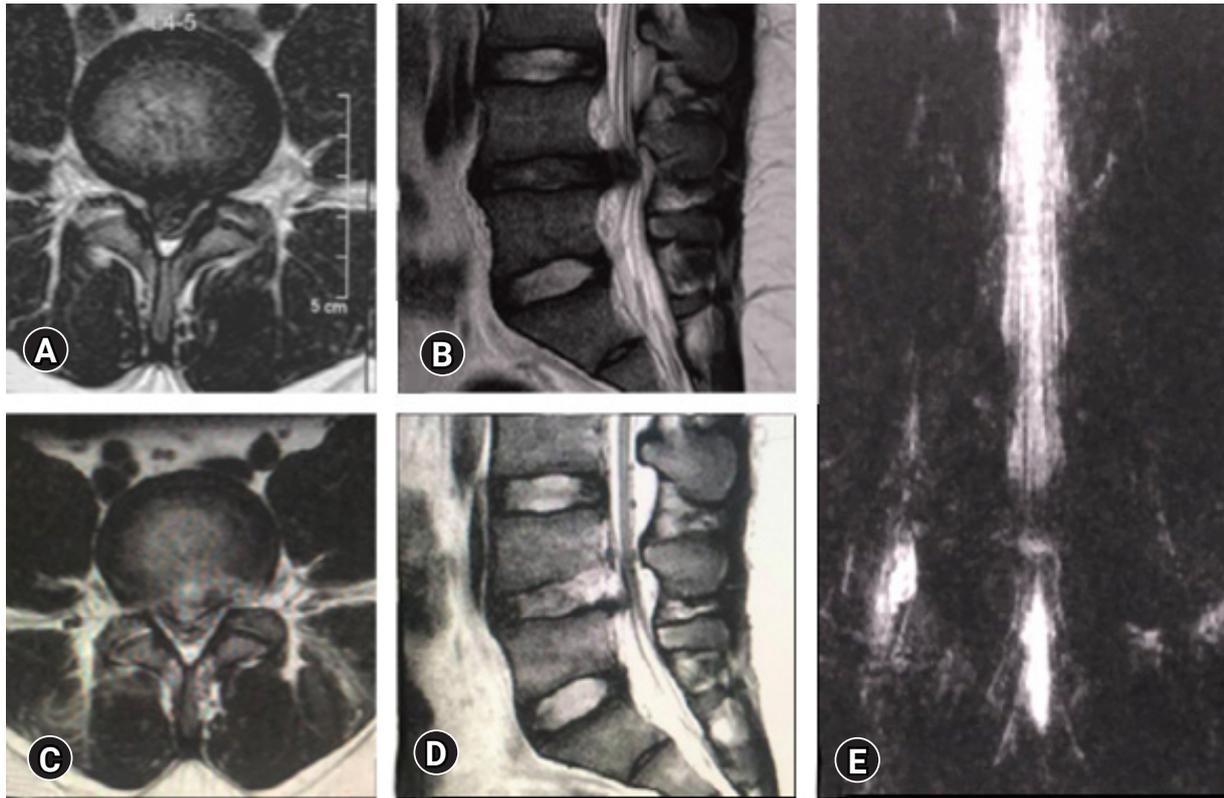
False Positive MRI myelo-block. In spite of removal of the culprit fragment and EPD achieved with soft dural flutter, opposite annular fissure visualization), epidural probing, and annular flap mobility, a pseudobulge is visible on the post-operative MRI. The patient was non-symptomatic and excellent clinical outcome.
